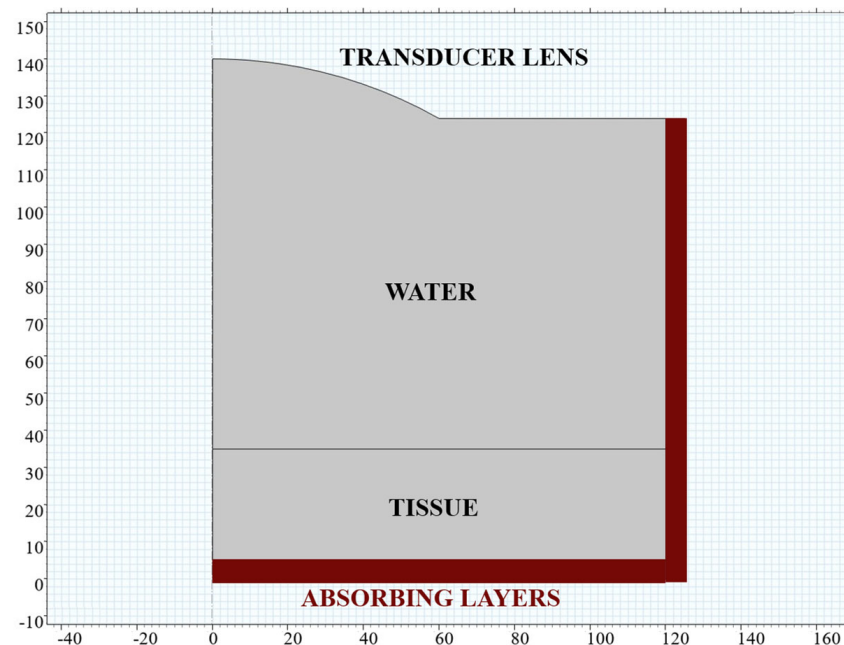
Geometry of the computational model. A focused ultrasound transducer equipped with a concave lens emits the acoustic signal through 105 mm of water, used for acoustic coupling, and into 30 mm of tissue. The thermal lesion is expected to form at the focal length of the transducer ($F = 120$ mm). Absorbing layers are added to the geometry as perfectly matched layers (PML) to define the boundary conditions and minimize wave reflections.
